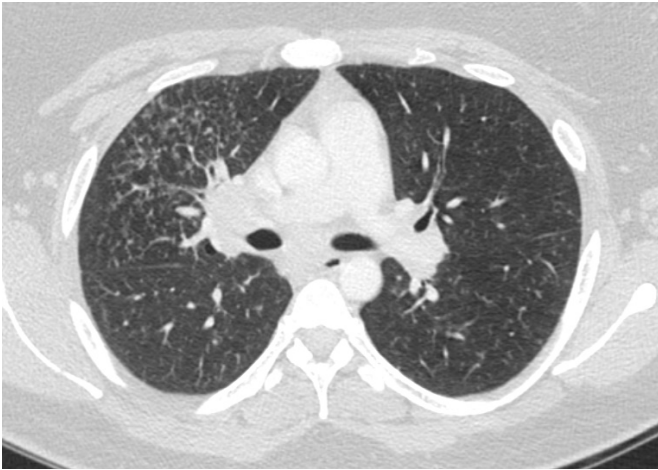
Chest CT scan without contrast.
